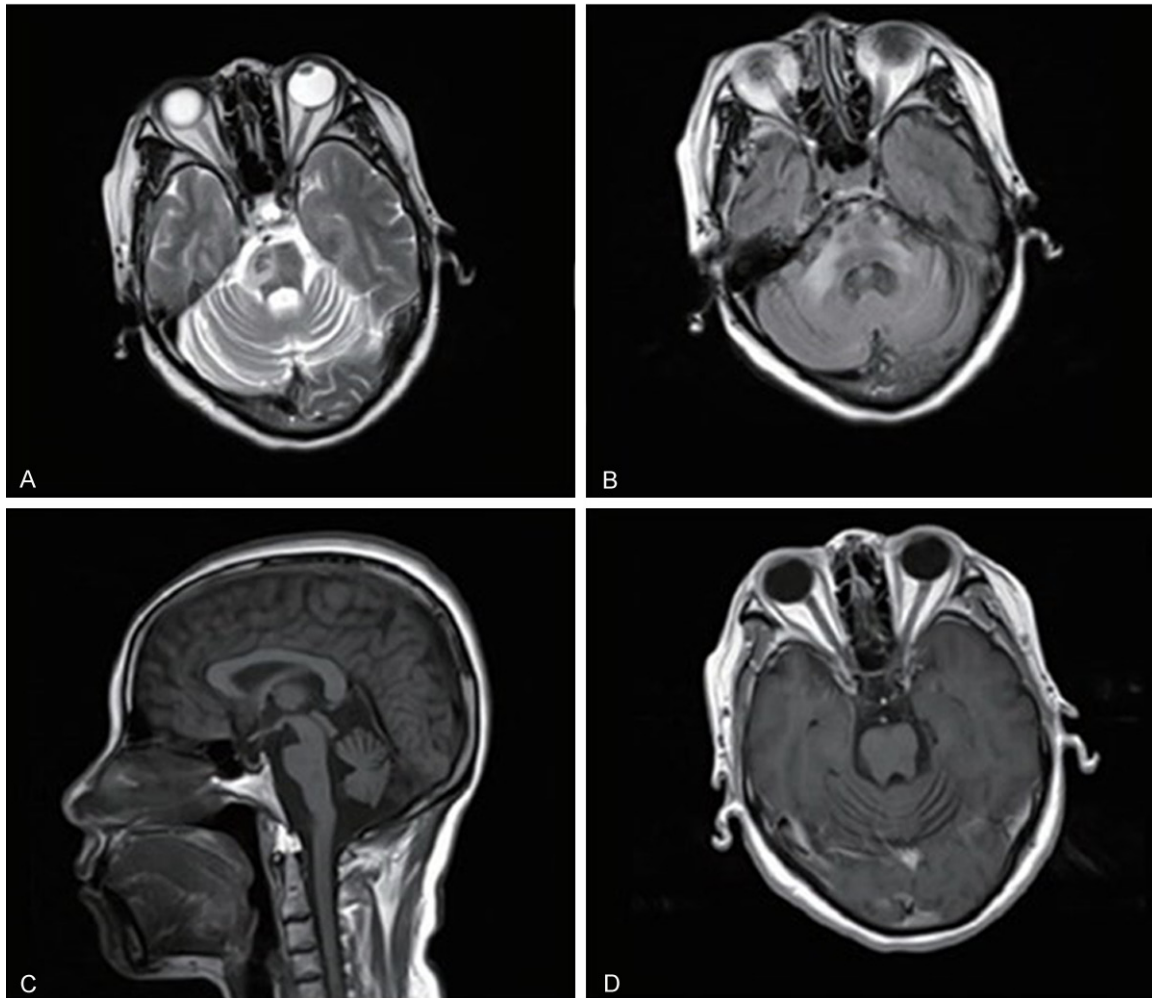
A: MRI-T2 weigh showed mixed signals in right pons; B: MRI-T2 weight showed signal in right brachium pons; C: Showed cerebellum atrophy; D: Contrast-enhanced MRI showed no enhancement.
